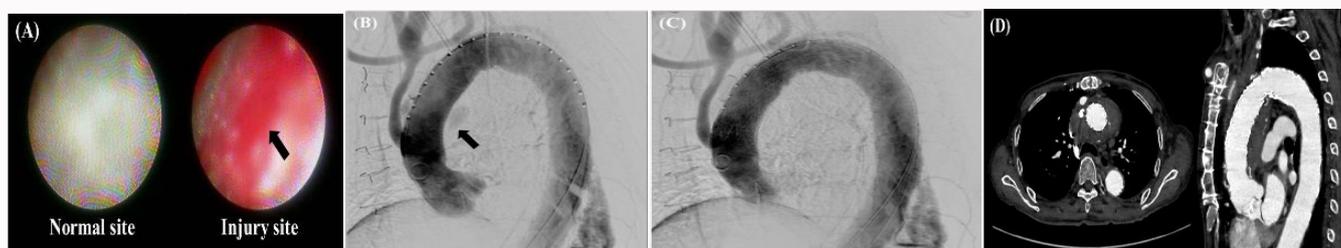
Aortic angiography and postoperative computed tomography findings.
